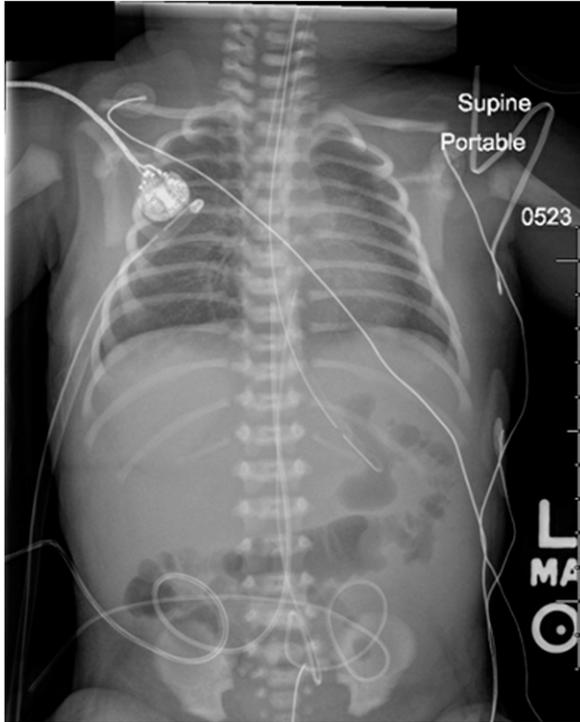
Chest radiography showing mild ground glass appearance.
